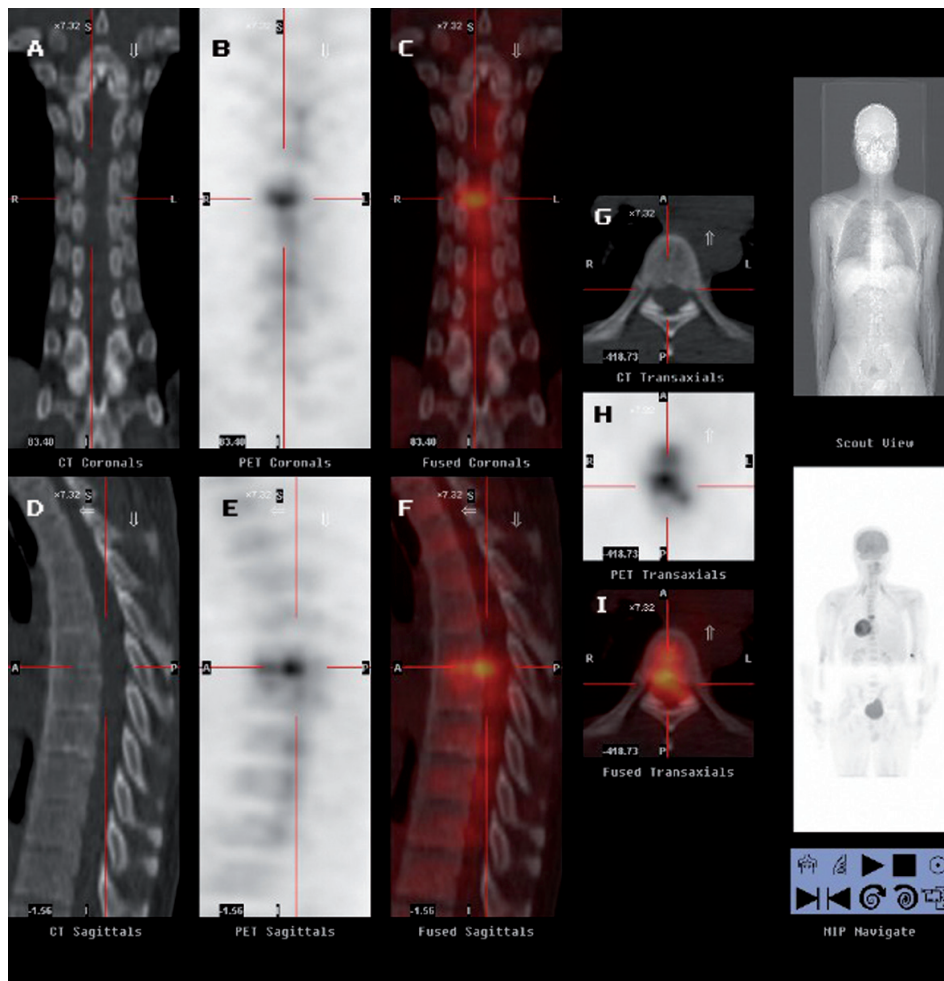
Images of patient's thoracic spine demonstrating the presence of inflammatory process in the intervertebral disc between T6 and T7. CT (A), PET (B), and fused (C) coronal view; CT (D), PET (E), and fused (F) sagittal view; CT (G), PET (H), and fused (I) transaxial view.
